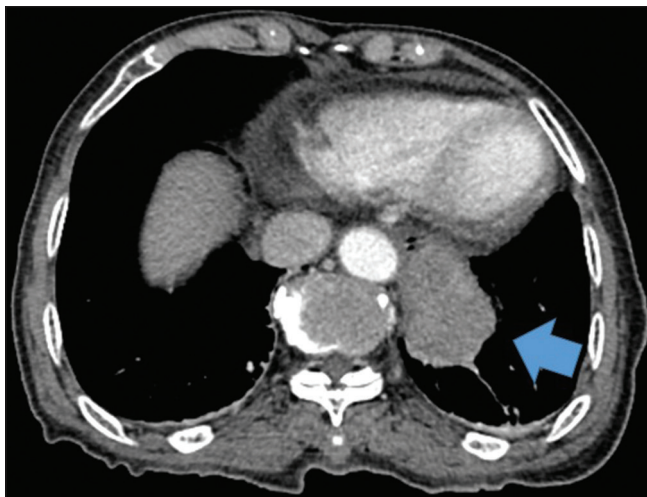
Contrast-enhanced computed tomography of the chest depicting a mildly lobulated homogeneous soft-tissue mass (blue arrow) with a circumscribed margin located over the posterolateral aspect of the lower third of the esophagus
